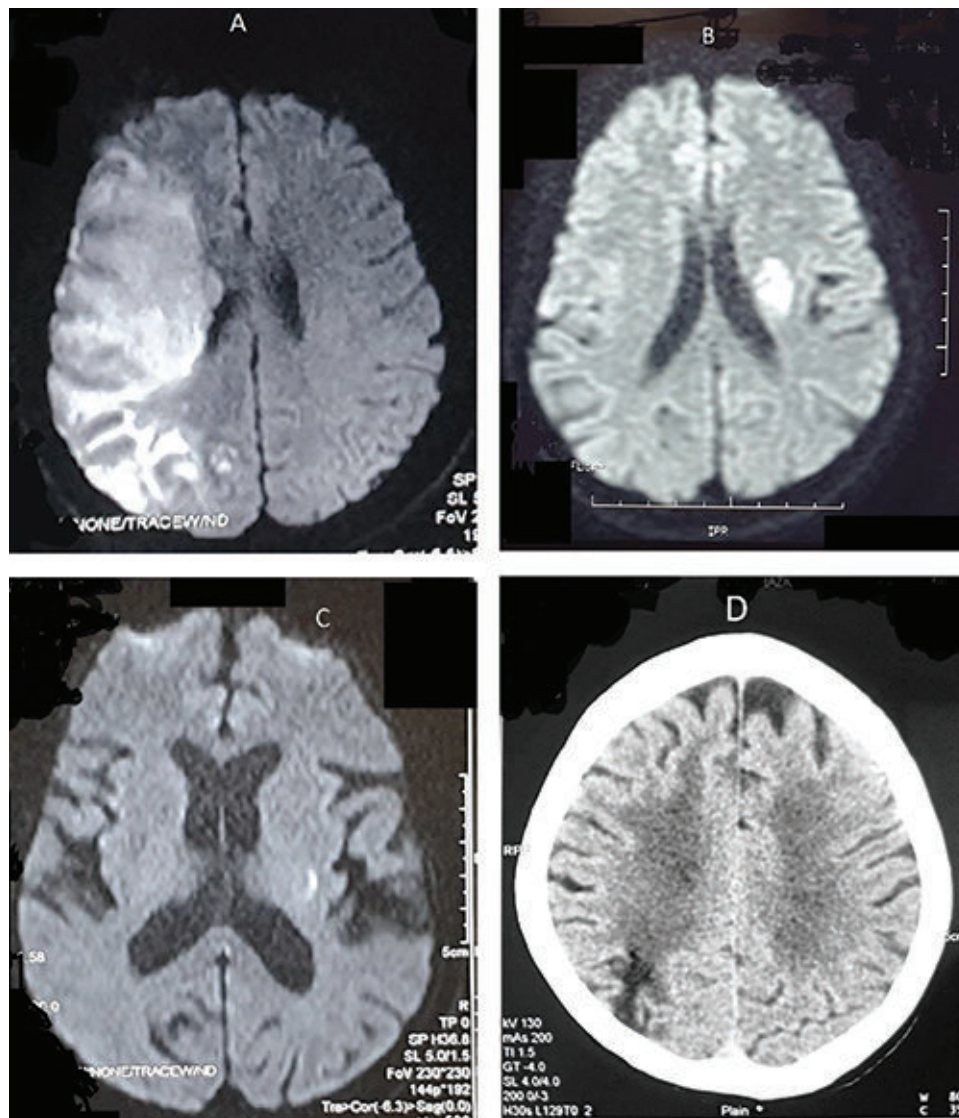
Definition of infarct pattern. A: MRI-DWI sequence showing territorial infarct involving right MCA territory. B: MRI-DWI sequence showing subcortical infarct involving left side. C: MRI-DWI sequence showing lacunar infarct involving left internal capsule. D: CT scan showing watershed infarct between right MCA and PCA territory.
